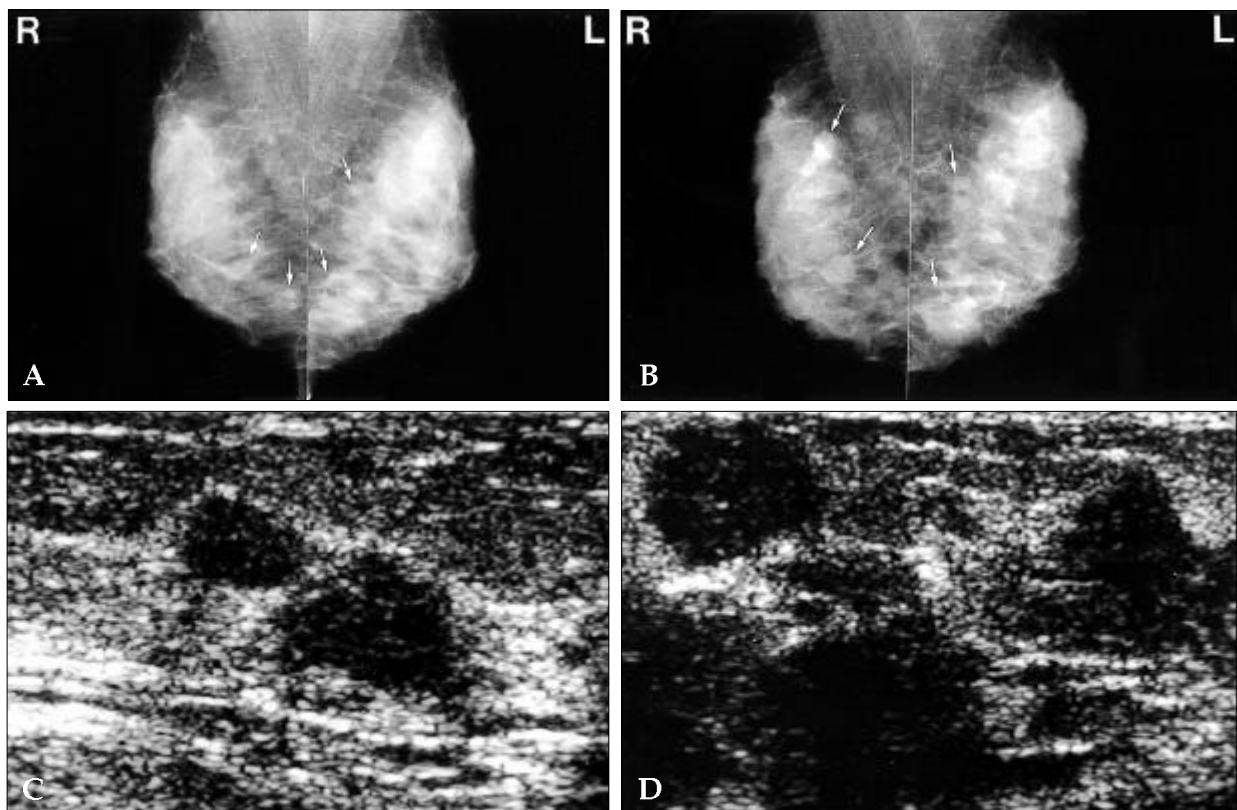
Hematogeneous metastasis to the breast from calf melanoma in a 40-year-old woman. (A) At the time of diagnosis of breast metastasis, mediolateral oblique mammogram of both breasts shows several irregular shaped, high-density nodules with ill-defined margin (arrows). (B) After 1 month, multiple nodules (arrows) in both breasts grew in size and became more numerous on mammogram. (C) Breast ultrasound obtained at the first examination shows multiple irregular hypoechoic nodules with ill-defined margin. (D) After 1 month, multiple nodules in both breasts increased in size and became more irregular on ultrasound.
